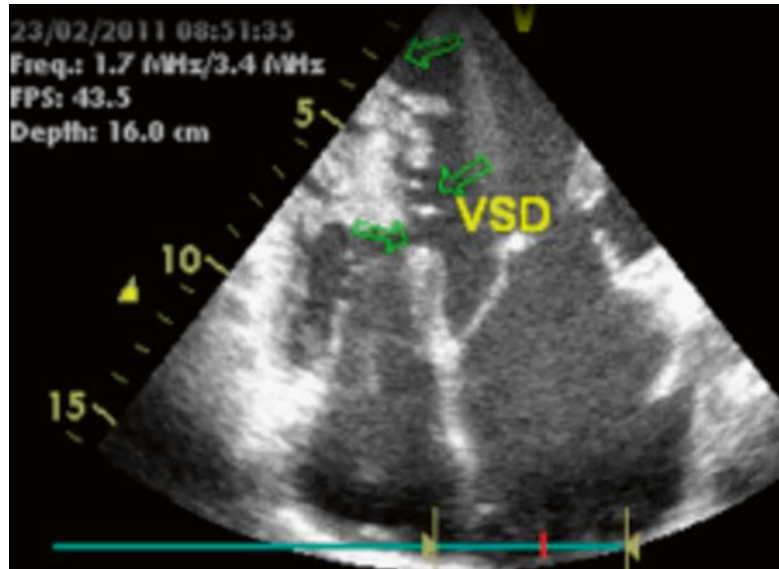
Transthoracic echocardiography in 4-chamber view showing multiple midmuscular VSD (Swiss cheese septum) associated with left heart enlargement
